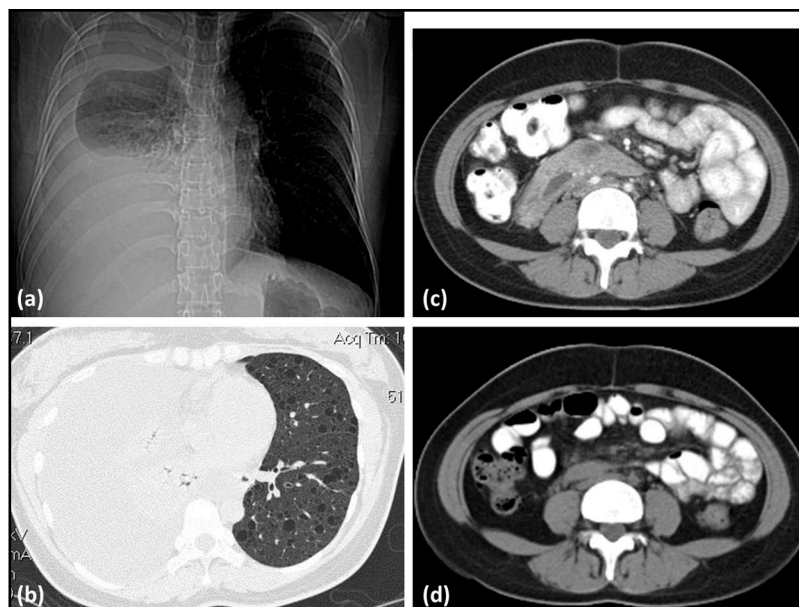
Chest radiograph (a) and HRCT (b) images of a 37 year old female with a right-sided chylous pleural effusion and cystic changes due to LAM. CT of the abdomen (c) revealed a retroperitoneal mass with hypodense center that was associated with a protein losing enteropathy, suggesting communication with the gut. Needle aspiration showed HMB-45 positive cells consistent with LAM. 1 year of Sirolimus therapy resulted in resolution of retroperitoneal mass (d).
